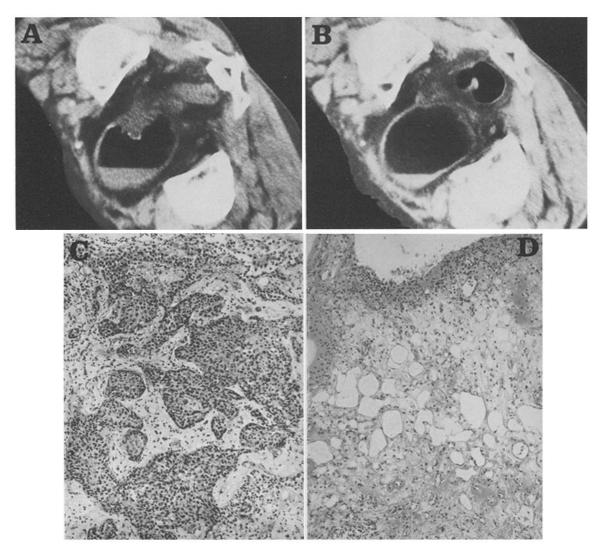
D. Radiographic and pathological findings in case 23. CT scan prior to the treatment [A] shows T3 bladder tumor; postoperative CT scan [B] reveals complete remission of the tumor. Pre-operative biopsy [C] shows grade 3 transitional cell carcinoma, and post-operative biopsy [D] reveals grade IVb pathological effect
